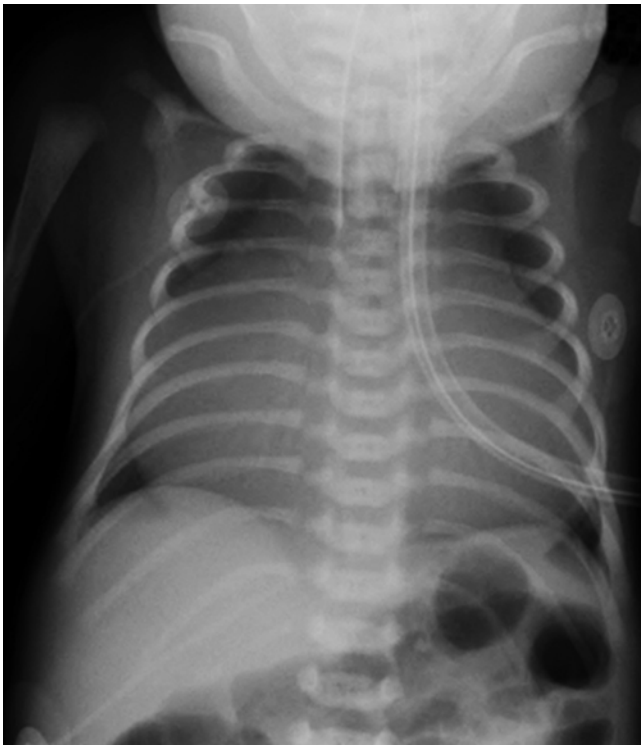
Chest radiograph of a neonate with severe Ebstein's anomaly
